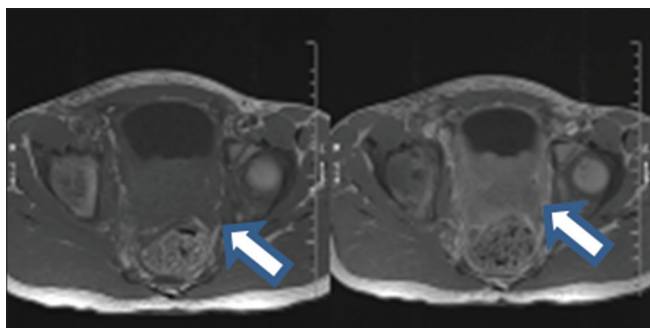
A pre- and post-contrast axial T1WI MRI pelvis image shows enhanced prostate mass with the central area of necrosis (white arrow).
